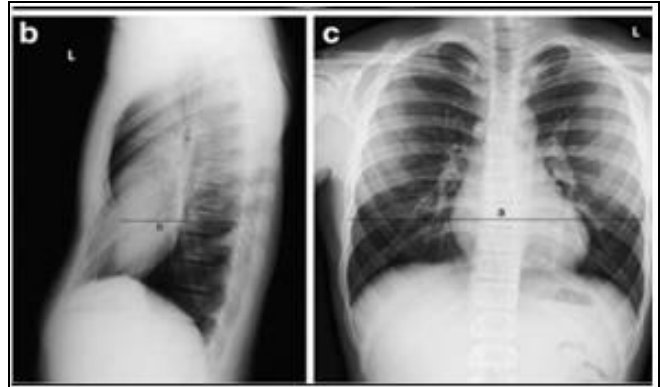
A horizontal line (line b) was drawn on the lateral radiograph from the deepest portion of the sternum to the anterior margin of the vertebral body. The level of this vertebral body was ascertained by counting from the 12th rib. The transverse diameter (line a) of the chest was determined at the same vertebral body level on postero-anterior view of chest. The ratio of these two lines (a/b), was the radiographic Haller's index
